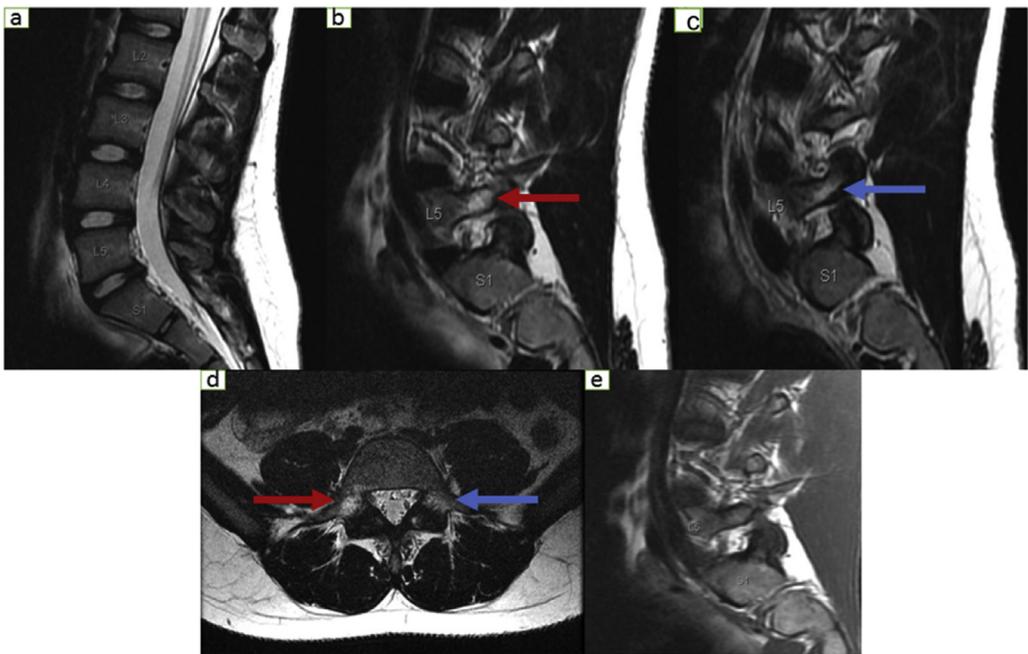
(a) Sagittal T2W MR image of the lumbar spine shows normal alignment. No spondylo-lysthesis. (b, c) Right and left parasagittal T2W, and (d) axial T2W images show hyperintense signal (red arrow) in the right L5 pedicle and pars interarticularis extending into the superior articular process compatible with bone marrow edema (stress reaction). Similar subtle signals are evident in the posterior left L5 pedicle (blue arrow). No definite hypointense signal to suggest pars interarticularis defect on (d) T1W Sagittal image.
